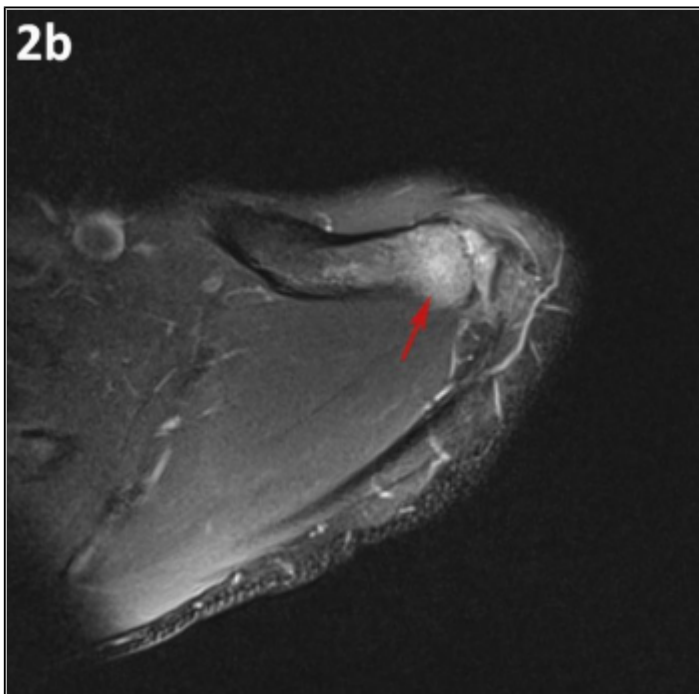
arthro-MRI of the left shoulder
